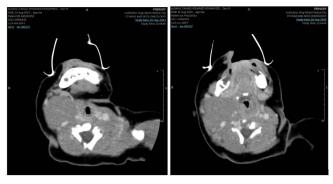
CT neck showing The lesion is displacing the right jugular vein and carotid artery medially and posteriorly.
